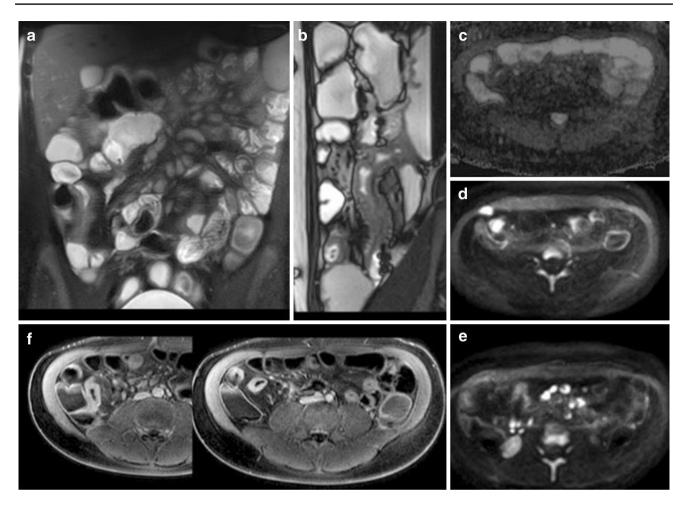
A 13-year-old boy with re-active Crohn's disease (CD). Coronal (a) and sagittal (b) SSTSE T2-weighted with fat suppression images show significant pathological ileal involvement with multiple enlarged mesenterial lymph nodes. ADC map (c) and DWI image (d, e) show parietal restriction of diffusivity in the *right* pathological ileal loops and lower positivity in those in *left* quadrants with positive
